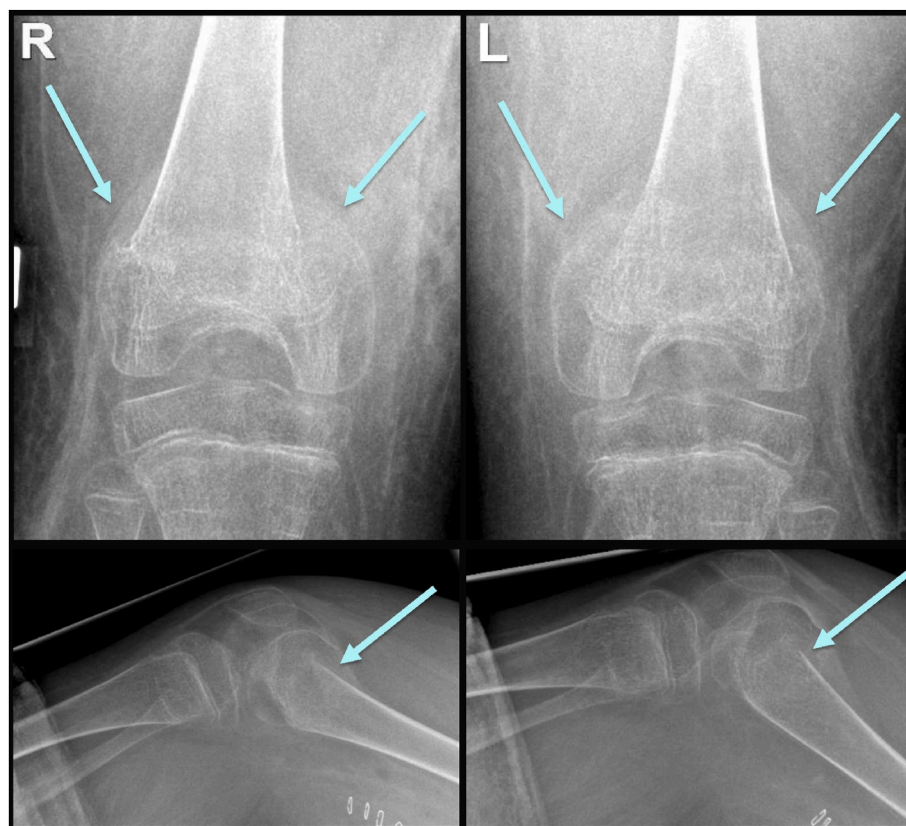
Post-operative X-ray imaging of lower extremities of right and left distal femur – knee – tibia, demonstrating pronounced osteopenia and recent severe compression fractures of both distal femora (arrows). Upper images: anterior-posterior, lower images: lateral; R right, L left.
